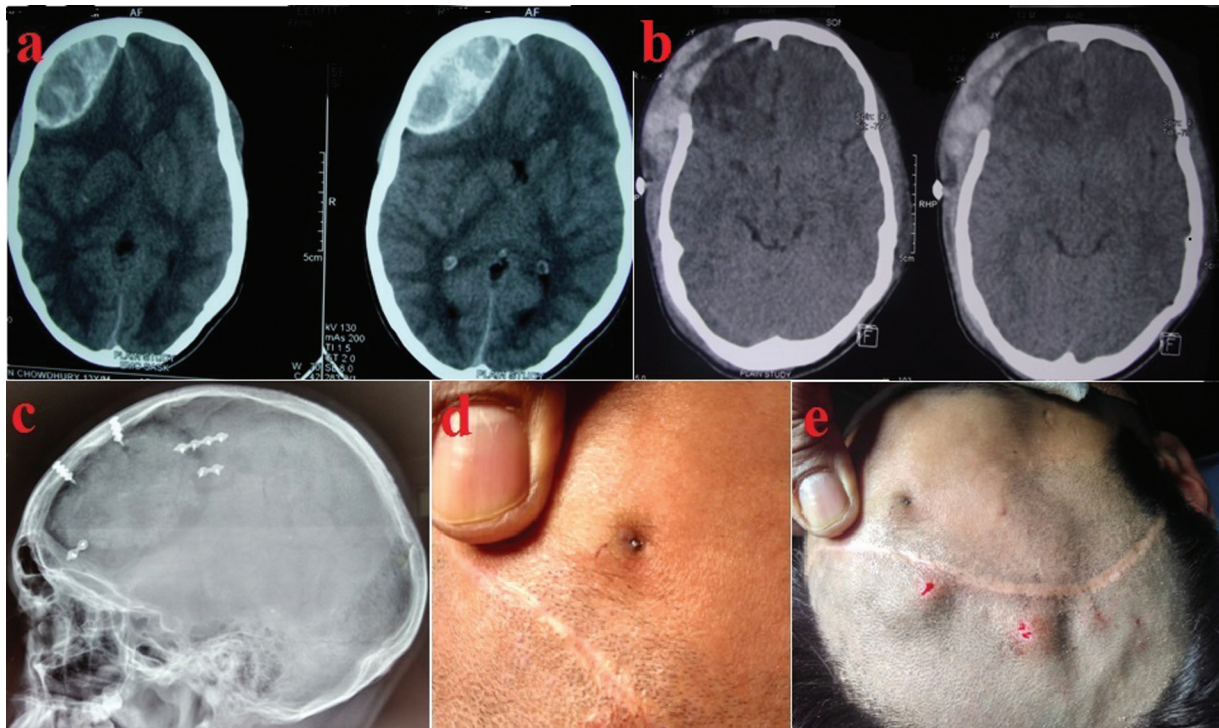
Preoperative CT scans (A) of a patient with right sided extradural hematoma; postoperative CT scans (B) after DC and clot evacuation; post CP skiagram (C) showing the implants used to anchor the bone flap and clinical photographs (D,E) showing erosion of implant through the skin at one place and elevation of the wound at two other places due to implant back out.
